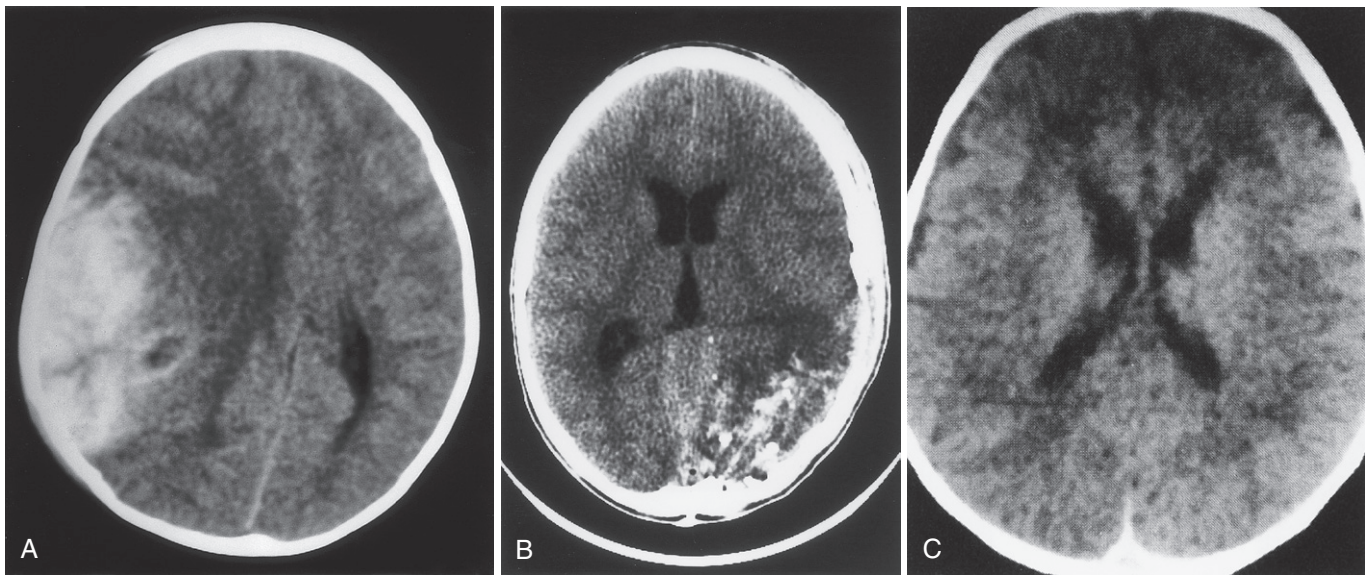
Axial cranial CT images of important lesions in pediatric traumatic brain injury including (A) acute epidural hematoma (B), penetrating brain injury resulting from a gunshot wound (with bullet fragments), and (C) inflicted childhood neurotrauma (shaken baby syndrome) with a subtle posterior subdural hematoma.
